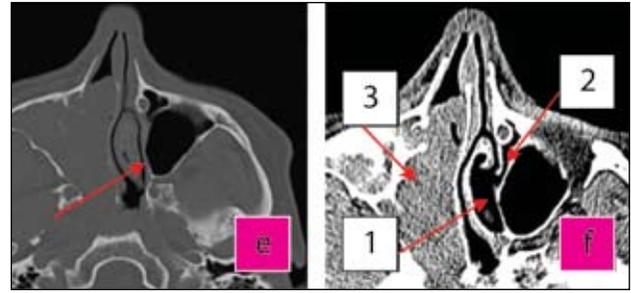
a, b, c, d Cranio-facial CT, axial slices. a,b: tissue window;c,d: bone window. a. Pneumatization of the left anterior clinoid process; b. partial pneumatization of dorsum sellae; c. Hyperpneumatization of the left sphenoid sinus, posterior development towards dorsum sellae; d. concha inside the left concha bullosa
